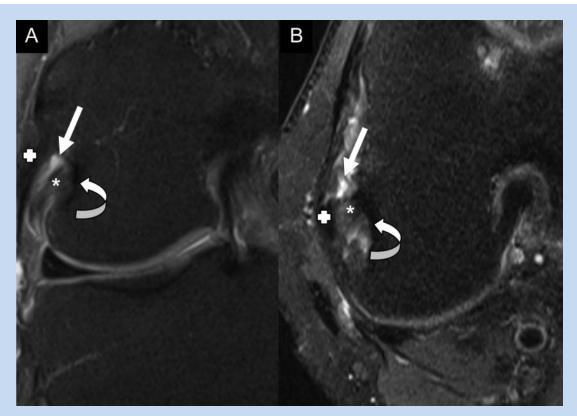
Coronal (A) and axial (B) proton density fat-suppressed magnetic resonance images of a knee show a small cystic structure (straight arrows) within the anterior margin of the popliteus tendon (asterisks), reflecting a ganglion cyst. Notice the mild hyperintensity of the popliteus tendon reflecting mucinous degeneration. Curved arrows indicate popliteus sulcus of the femur; crosses indicate fibular collateral ligament.
